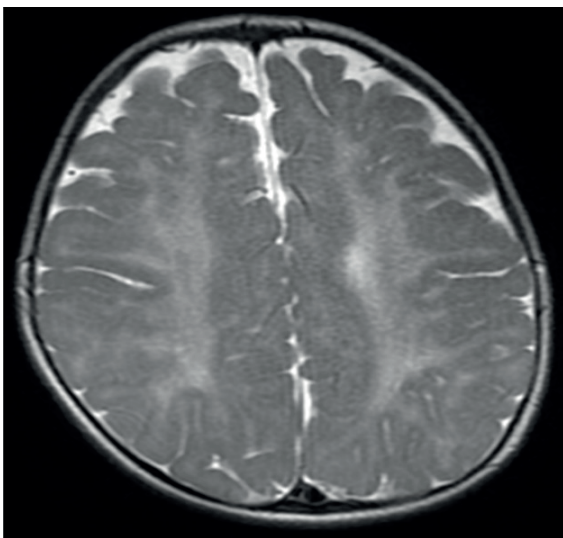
Magnetic resonance imaging (MRI) T2-weighted axial images showing almost symmetrical hyperintensities involving the peritrigonal, periventricular, subcortical, centrum semiovale, corona radiata regions.
